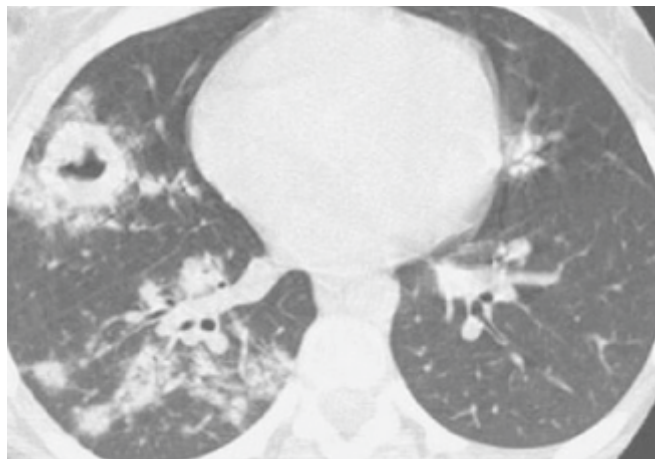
Chest CT : Multiple nodules with one showing cavitation on right side.
